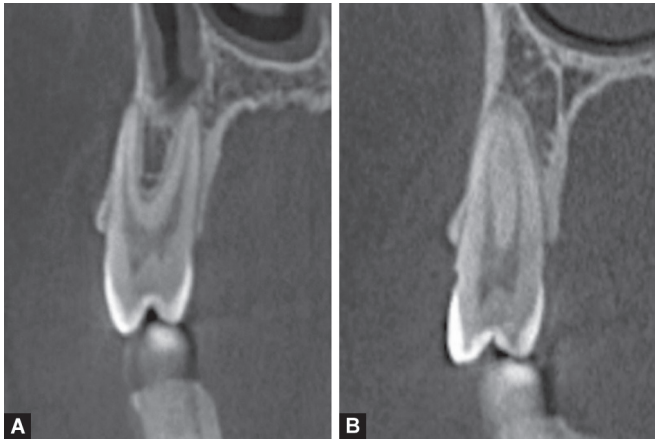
CBCT sagittal slides of maxillary first premolars showing; (A) 2-rooted 1st premolar with 2 canals and Vertucci type IV, (b) first premolar with 1 root and 2 canals, and type II Vertucci
